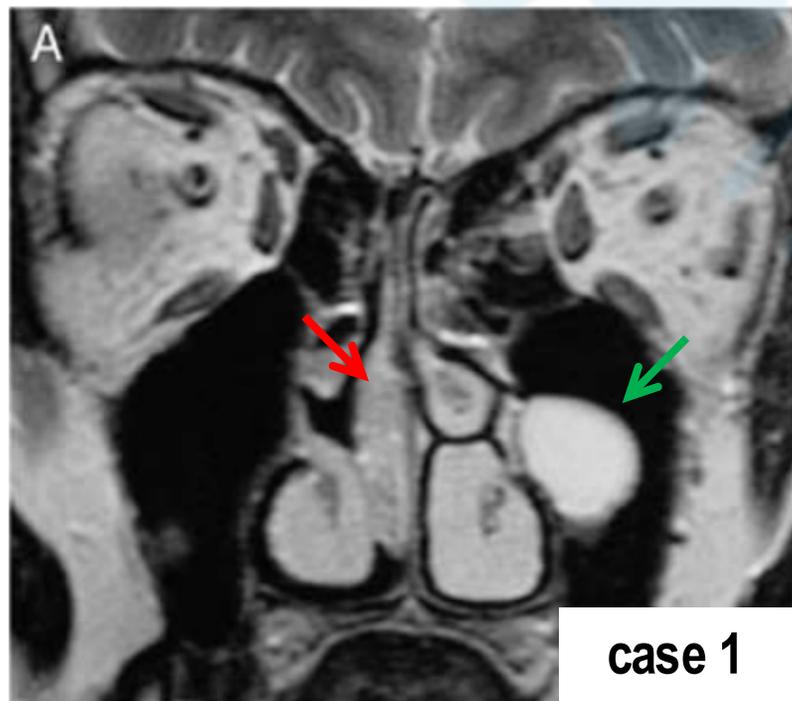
Imaging findings. A, Coronal T2-weighted MRI in patient 1. The lesion extends from the right olfactory cleft to the inferior turbinate and contains small hyperintense cysts. Note the hyperintense retention cyst in the contralateral maxillary sinus. B, Coronal T2-weighted MRI in patient 3. This large lesion exhibits a more heterogeneous signal, with small foci of hypointensity and hyperintensity signals corresponding to cysts. Note the left chronic anterior sinusitis resulting from obstruction of the left middle meatus. C, Axial T2-weighted MRI in patient 6. The mass is lodged in the right sphenoidal recess, partially filling the right sphenoid sinus, and is associated with mucosal thickening and obstruction of secretions.
